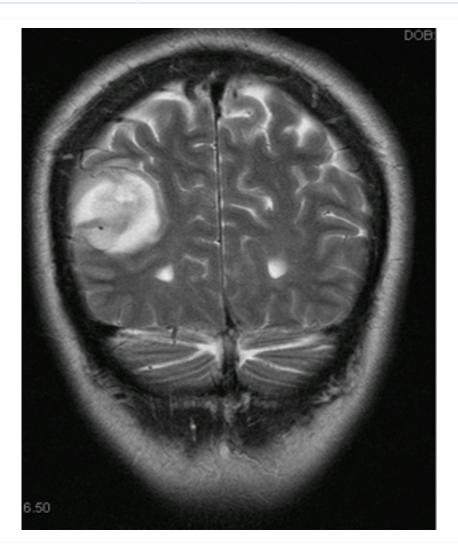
CT head showing right parietotemporal brain tumor
